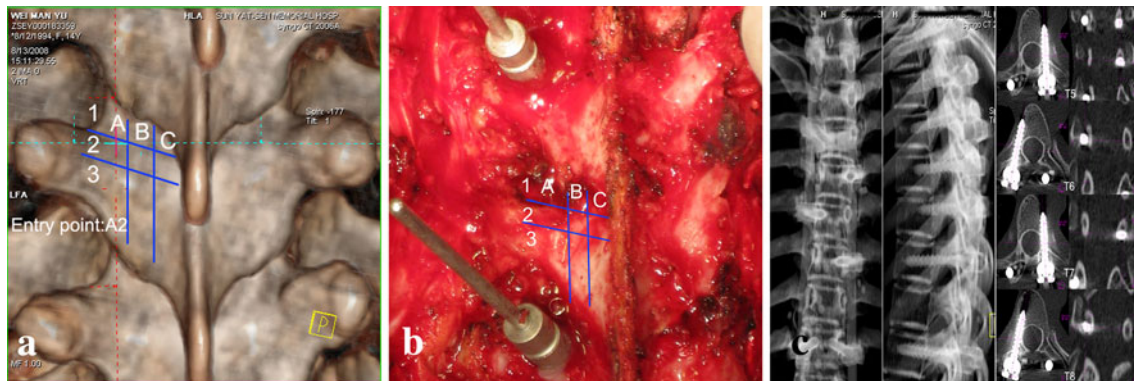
The nine areas system was used to help locating the reconstructive entry point. a The entry point was decided preoperatively locating at A2 area. b The A2 area of the in vivo spine was identified as the entry point. c The evaluation of screw placement using MPR with CT scan
